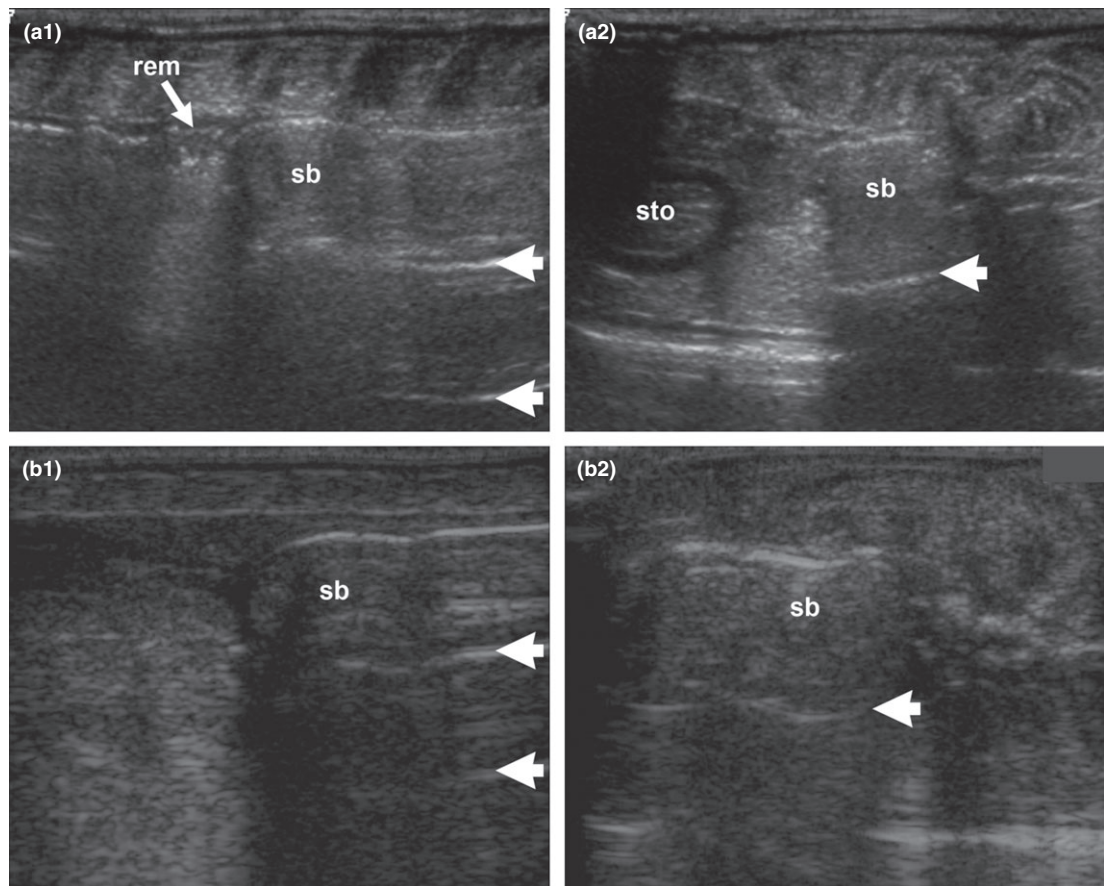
Anguilla anguilla*, no. 1. (a1) Longitudinal and (a2) transverse high-end ultrasonic images of halfway through the swimbladder in Fig. 4 taken with a 14 MHz linear transducer, showing the swimbladder (sb) and stomach (sto) with reverberation artefacts (short arrows). (b1) Longitudinal and (b2) transverse low-end ultrasonic images of the same swimbladder taken with a 5 MHz linear transducer showing the swimbladder (sb) with reverberation artefacts (arrow heads).
